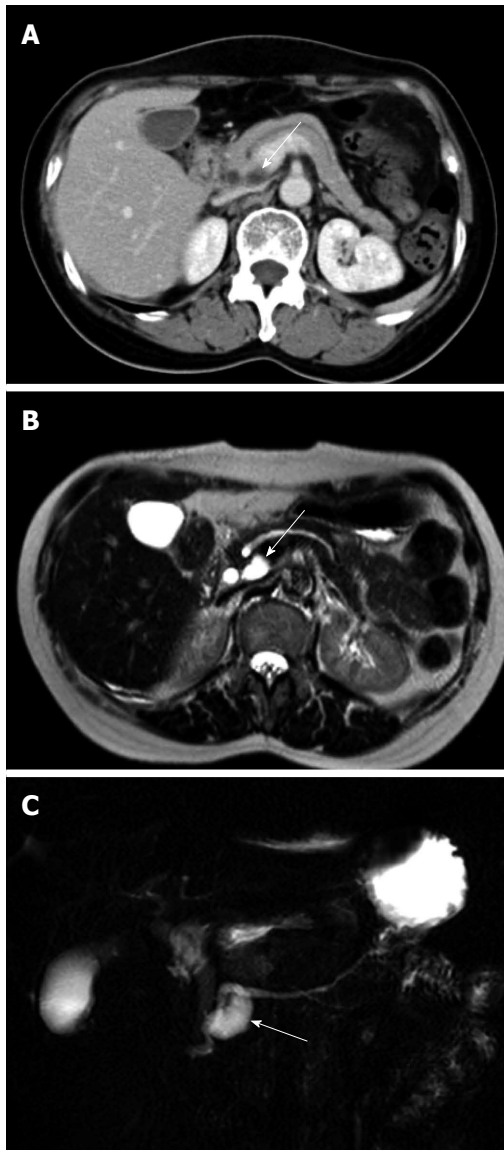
Contrast-enhanced computed tomography scans and T2-weighted magnetic resonance images. Contrast-enhanced computed tomography scans obtained during the portal venous phase showing a tubular cyst in the neck of the pancreas (A; white arrow). Axial T2-weighted magnetic resonance image showing a T2 hyperintense tubular lesion (B; white arrow) in the neck of the pancreas. The tubular lesion (C; white arrow) was more clearly appreciated on two dimensional magnetic resonance cholangiopancreatography.
